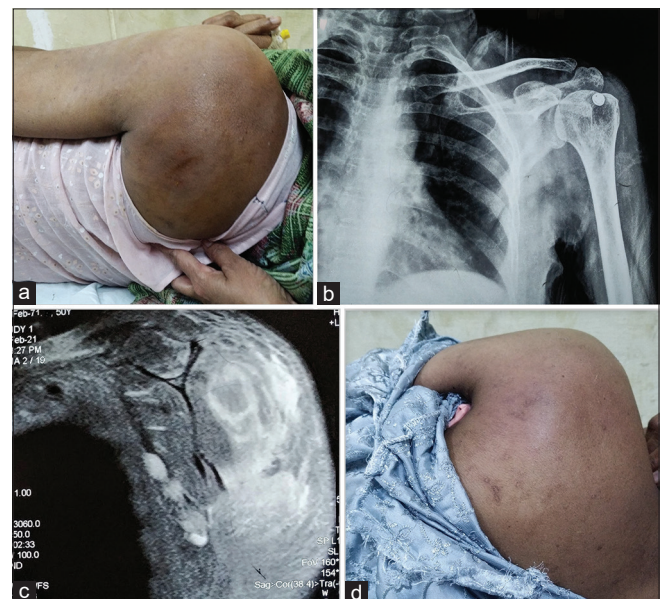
The clinical image showing a large boggy swelling involving the left scapular region (a) with radiograph showing no bony abnormality (b). MRI image showing extensive edema and collection in the infraspinatus muscle extending also below the scapula (c). The decreased swelling noted in the follow-up following few aspirations (d)
